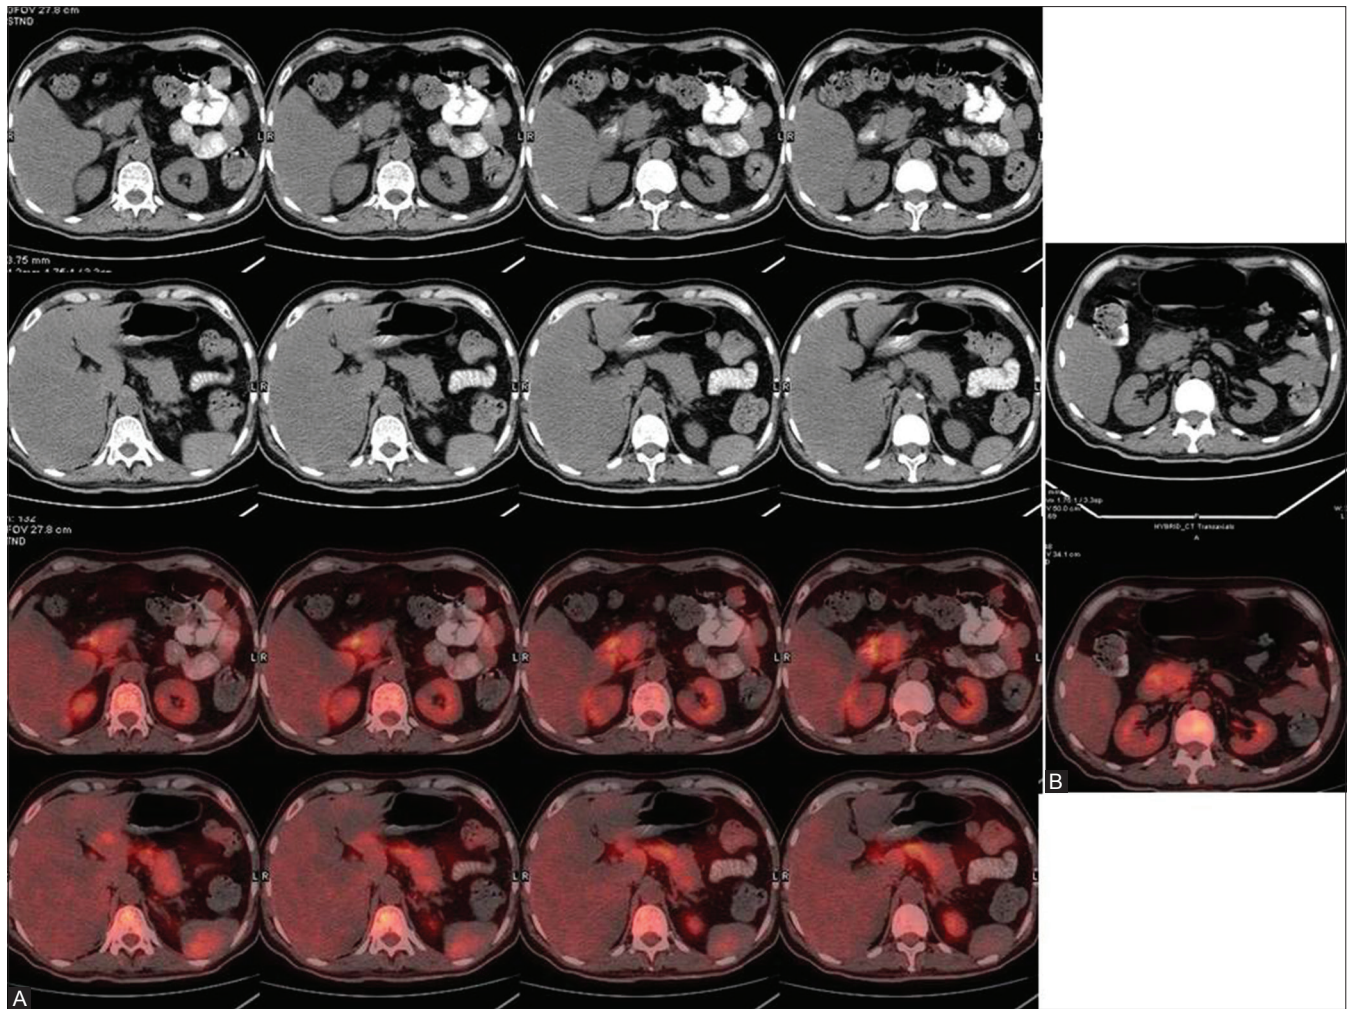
(A and B): (A) CT and axial fused ¹⁸F-FDG PET/CT images of the upper abdomen: Diffuse to heterogeneous moderate grade ¹⁸F-FDG uptake in entire pancreas, which appears relatively bulky with subtle peripancreatic fat stranding. (B) Delayed fused CT and axial fused ¹⁸F-FDG PET/CT images: persistent tracer retention in pancreas
